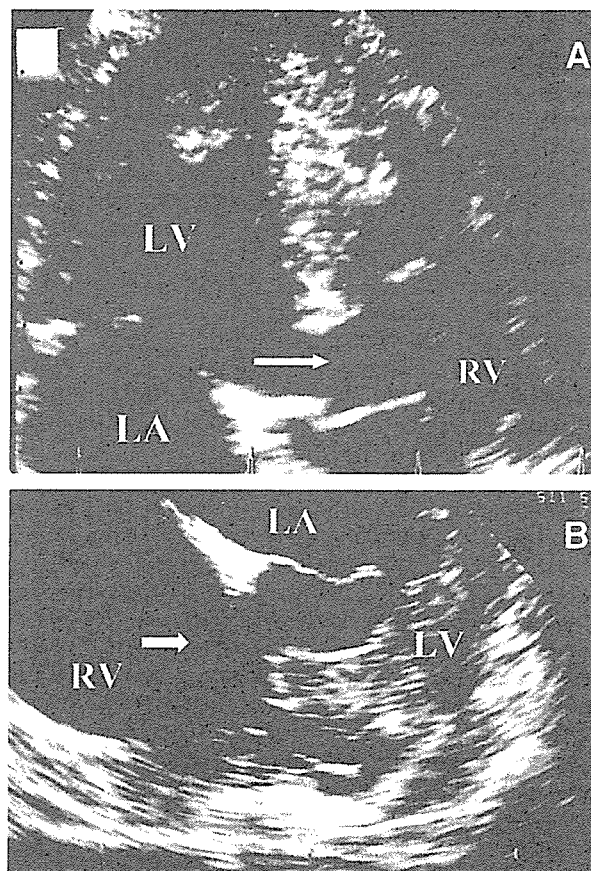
(A,B) Preoperative transthoracic and transesophageal echocardiograms in the 4-chamber view showing the tricuspid pouch at inflow of the right ventricle. LA, left atrium; LV, left ventricle; RV, right ventricle.
